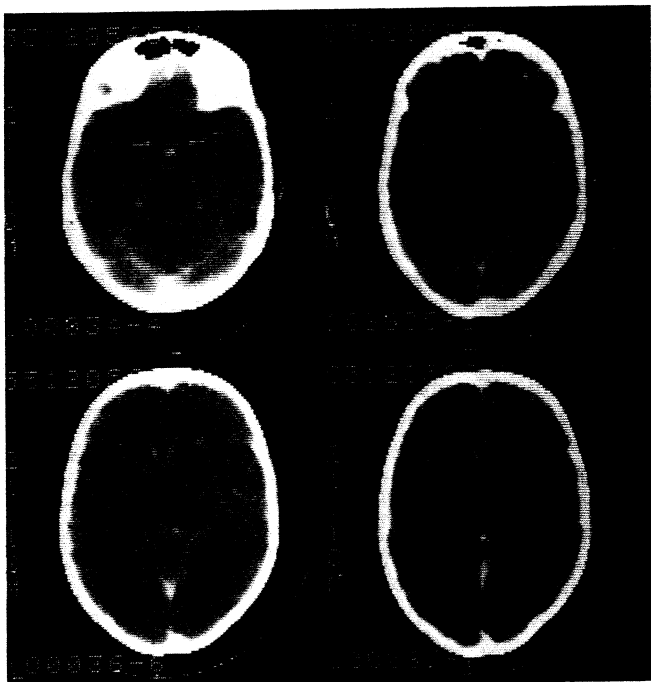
Case 1, CT scan with enhancement. There is a mass within the floor of the third ventricle extending into the suprasellar cisterns. A remarkably small mass can be seen in the pineal region with involvement of the quadrigeminal plate. Several enhancing lesions within the wall of the lateral ventricles indicate transventricular spread of the neoplastic process. A mild obstructive hydrocephalus is present.
